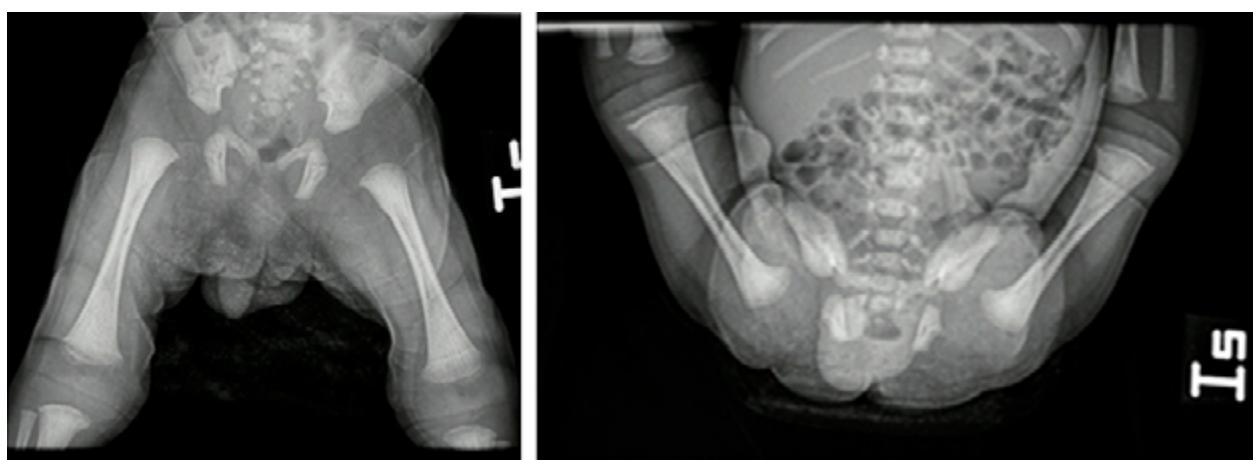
Pelvis x-ray in newborn with hyperextension of the knees.
